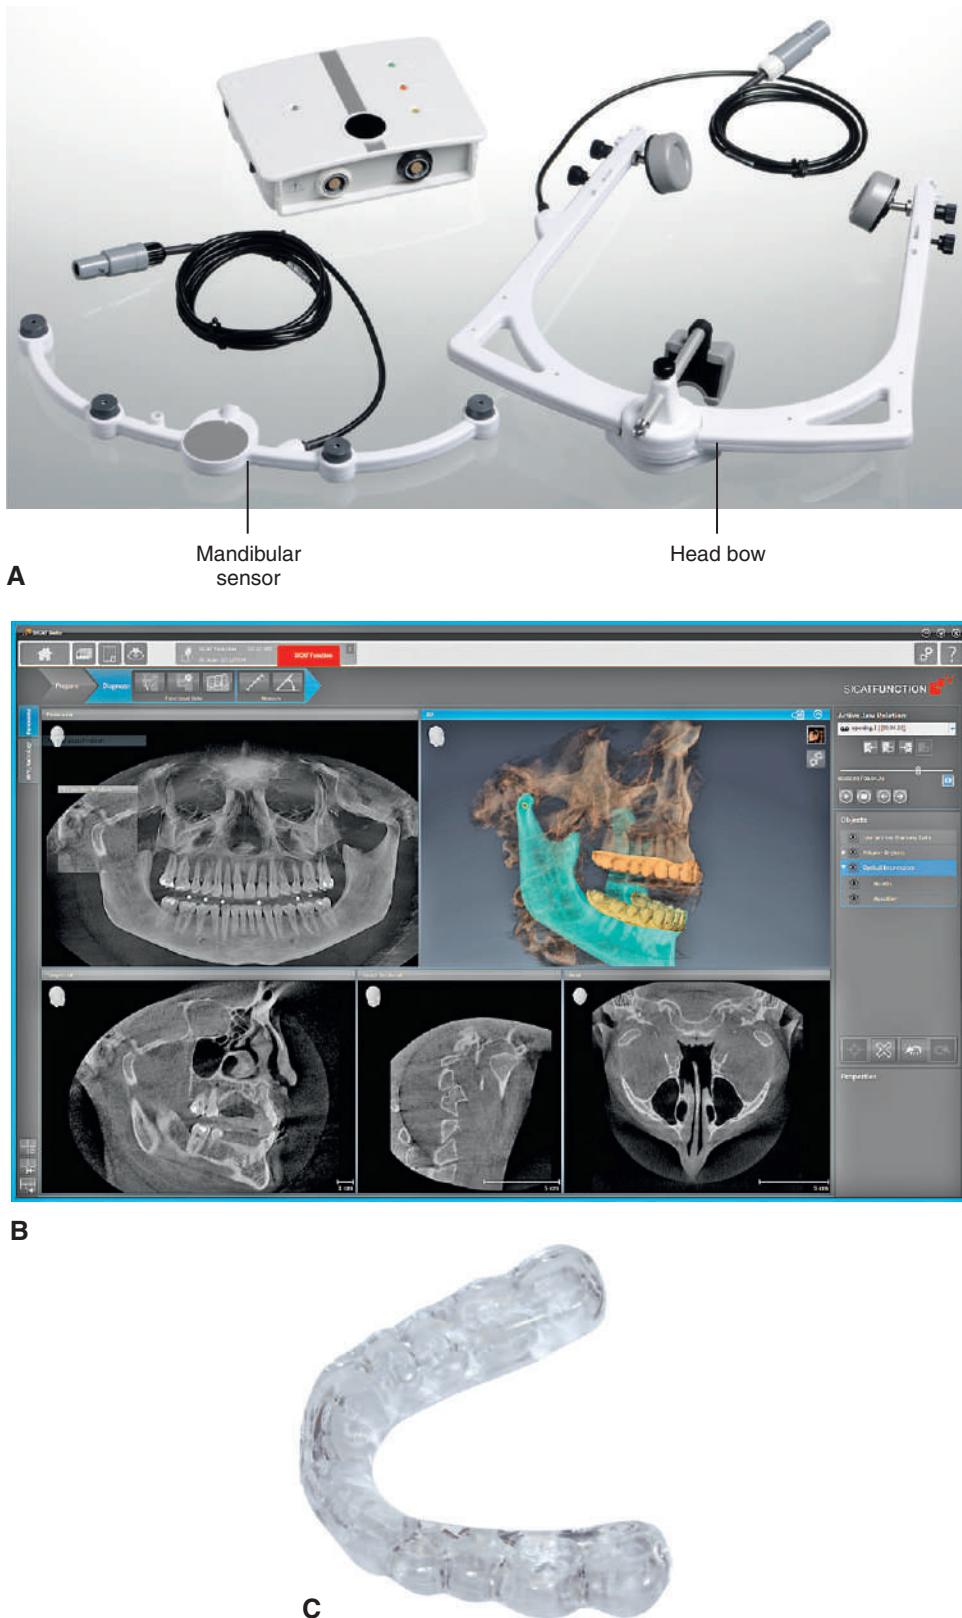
The SICAT Function software system integrates diagnostic information from a three-dimensional radiographic system, a mandibular motion tracking system with optical impressions (CEREC, Sirona). (A) The SICAT Jaw Motion Tracker recording equipment. (B) SiCAT Function software sample screen. The manufacturer reports patient-specific three-dimensional presentation of mandibular motion at any point of the mandible, as well as dynamic reproduction of the condyle-fossa relationship. (C) SICAT Optimotion treatment device fabricated on the basis of the three-dimensional radiographic data, the optical surface scan data, and the recorded movement data. (Courtesy of SICAT GmbH & Co. KG, Bonn, Germany.)
